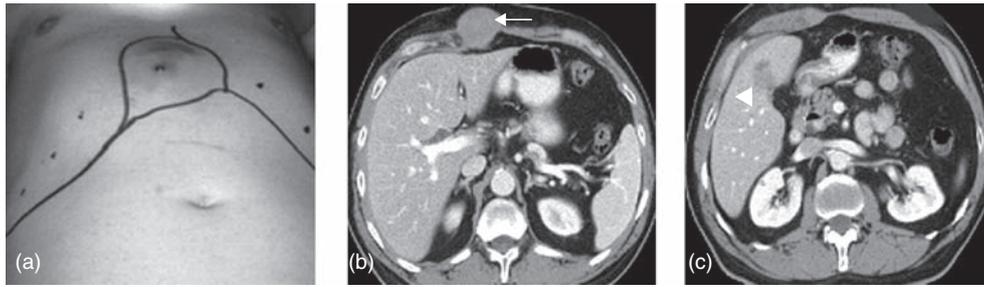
Port site recurrence in gallbladder carcinoma. (a) This patient developed a clinically obvious port site recurrence of gallbladder cancer at his midline subxiphoid laparoscopic port. (b) The metastatic subcutaneous mass (arrow) is also seen on axial computed tomography imaging. (c) Unfortunately, port site recurrence, while technically resectable, is usually a harbinger for disseminated disease. This patient developed a left hepatic metastatic deposit (arrowhead).
